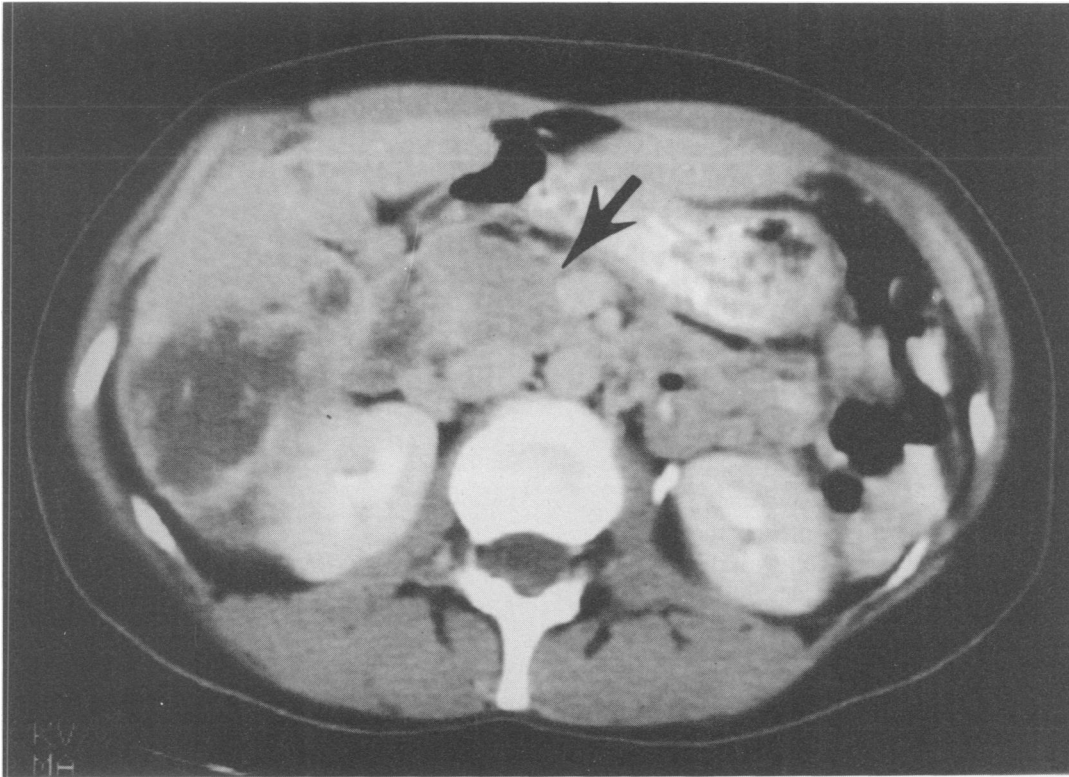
CT scan of patient 9, who had a very extensive carcinoma of the common duct with liver invasion, and with direct invasion of the head and body of the pancreas (arrow). Multiple lymph node metastases can be seen.
